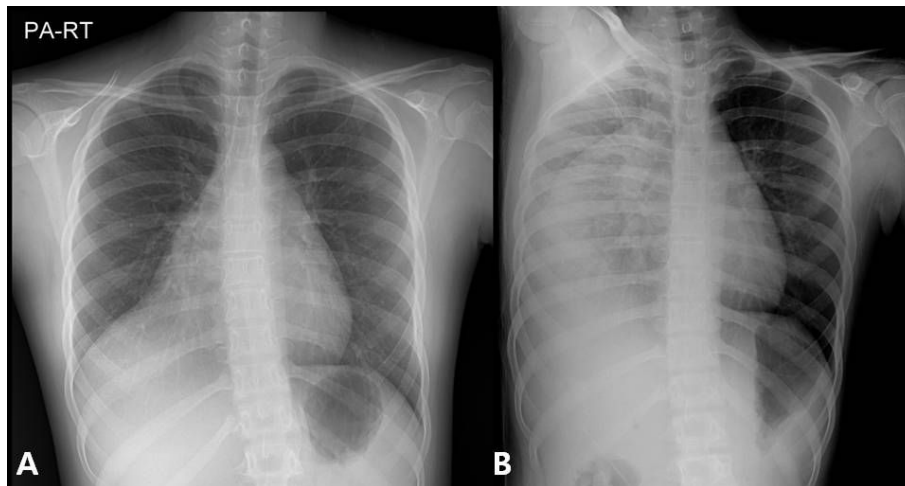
(A) Preoperative chest X-ray. Chest X-ray shows bulging mass shadow with obliteration of the entire right diaphragm and right cardiac border. (B) Preoperative right chest decubitus X-ray. The mass lesion shows plasticity in shape, according to positional change.
